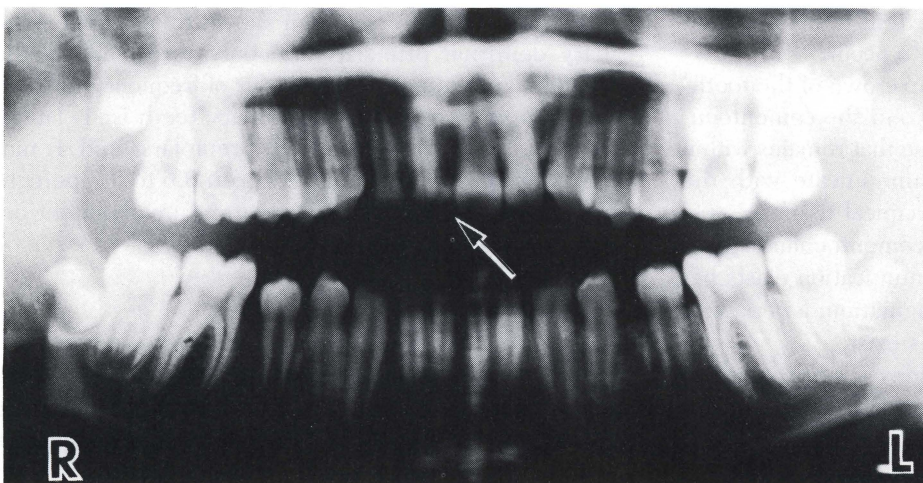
Panoramic radiograph reveals invagination of the maxillary right central incisor (arrow).
